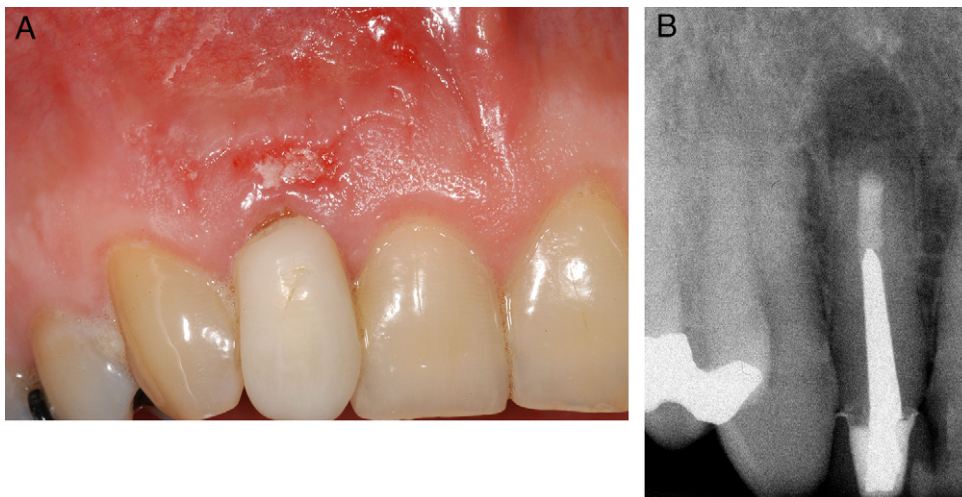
(A) The clinical situation after suture removal 4 days after apical surgery. (B) The postsurgical radiograph shows the root-end filling.
